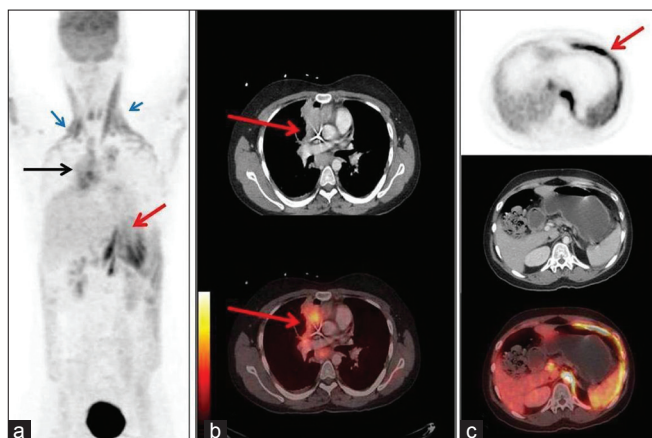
The positron emission tomography/computed tomography scan of a young male, showed increased fluorodeoxyglucose (FDG) uptake in right perihilar lung lesion [black arrow in Figure 1a and red arrows in Figure 1b] compatible with known lung neoplasm. Maximum intensity projection image also showed increased FDG uptake in accessory muscles of respiration-bilateral sternocleidomastoid and intercostal muscles [blue arrows in Figure 1a] and unilateral, intense FDG uptake in left hemi-diaphragm [red arrows in Figure 1a and c]. On CT, there was no morphological abnormality in any of the above-mentioned muscles with FDG uptake
